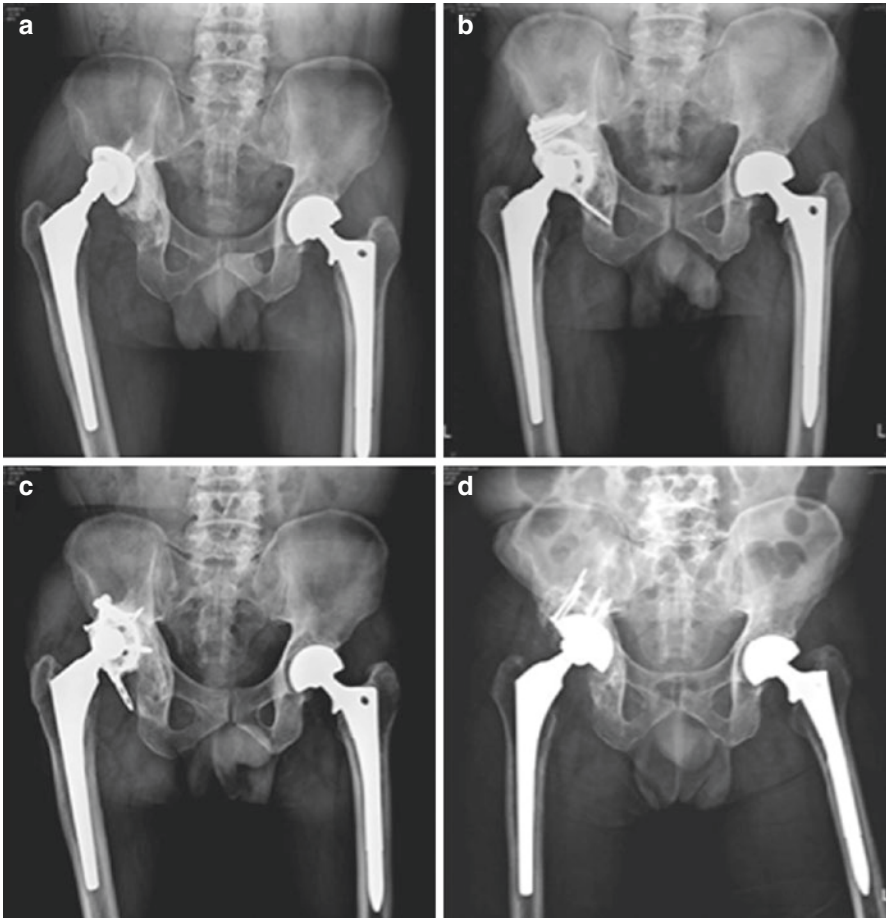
A 52-year-old man with aseptic loosening of the right THA. Radiographic and operative findings showed a 7×5 cm superoposterior deficiency of the acetabulum causing Paprosky type IIIA defect (a). Partial consolidation of the bulk allograft of the superior wall reconstruction and good position of reconstruction cage at 1-year radiograph were seen (b). However, because of no distal screw fixation and inadequate superior support of the cage without additional screw fixation from inside the cage, loosening of the cage with graft failure was seen 6.5 years after the index reconstruction (c). The failed cage was easily reconstructed with an uncemented primary acetabular component and a bulk allograft because of partial healing of the previous structural allograft in the superior wall (d) (these pictures were agreed by the patient for publication)
